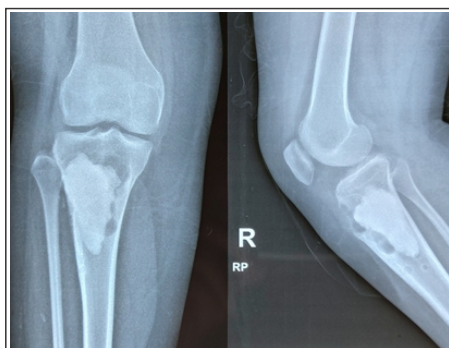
Post-operative radiographs (AP and lateral views) of the right knee joint showing filling of the cavity with bone cement.
